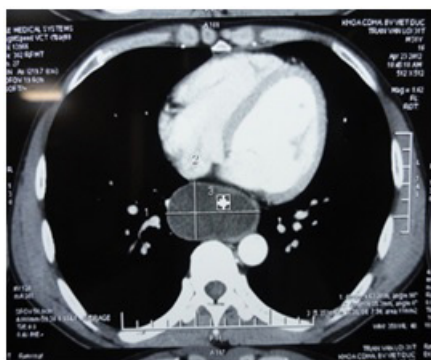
Image of esophageal duplication cyst on chest computed tomography
